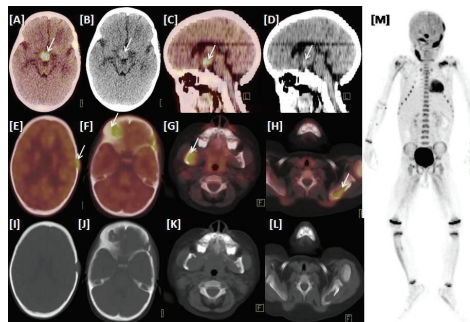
¹⁸F-Fludeoxyglucose Positron Emission Tomography-Computed Tomography (FDG PET/CT) scan revealed multiple FDG avid lytic lesions involving skull bones and tibia with increased FDG uptake. Incidentally, a focus of FDG uptake was noted in the hypothalamus in brain
